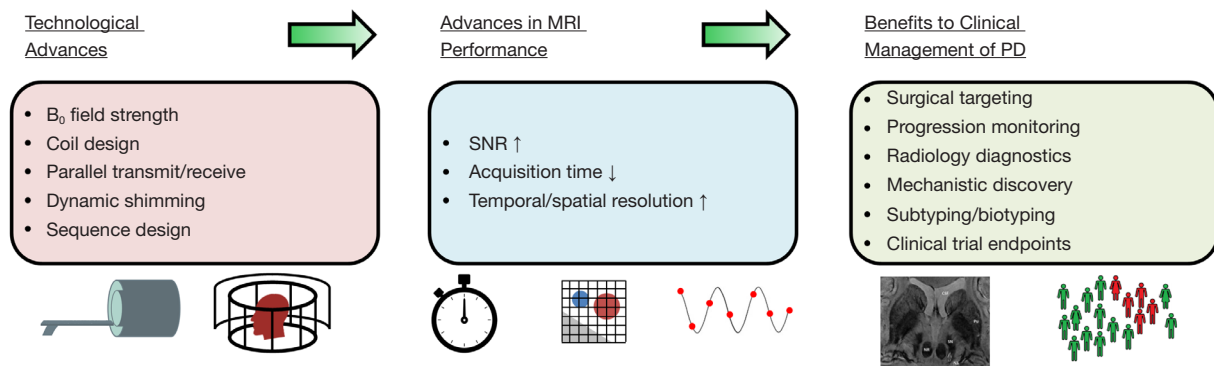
Overview of 7T MRI advances and benefits to PD imaging. The MRI image (right) was reproduced as-is, and was originally published under the Creative Commons Attribution 4.0 International (CC BY) license [Gramsch *et al.* 2017 (16)]. MRI, magnetic resonance imaging; SNR, signal to noise ratio; PD, Parkinson’s disease; 7T, 7 Tesla.
